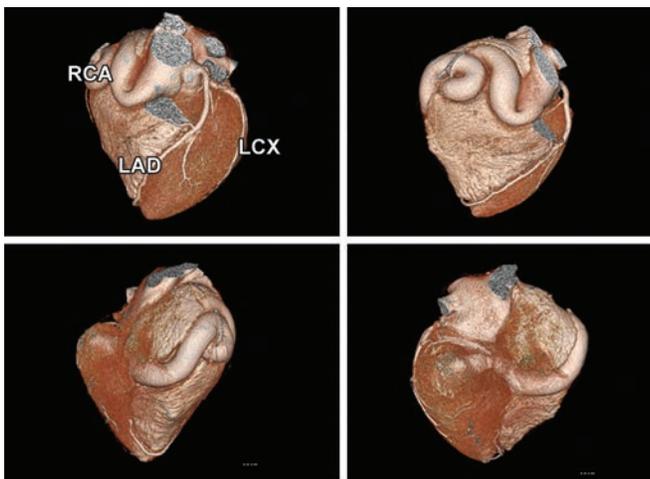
Computed tomographic angiogram showing the tortuous and dilated right coronary artery fistula.
